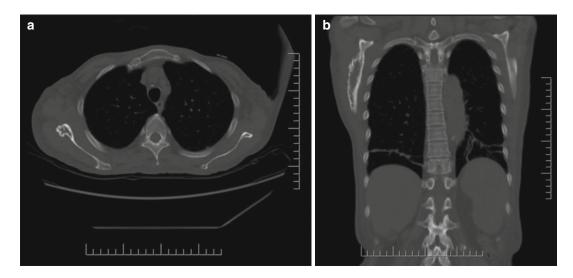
Axial (a) and coronal (*right panel*) CT scan with bone windows, showing the partly sclerotic and partly lytic nature of the lesion. Note splenomegaly in the coronal CT (b)
